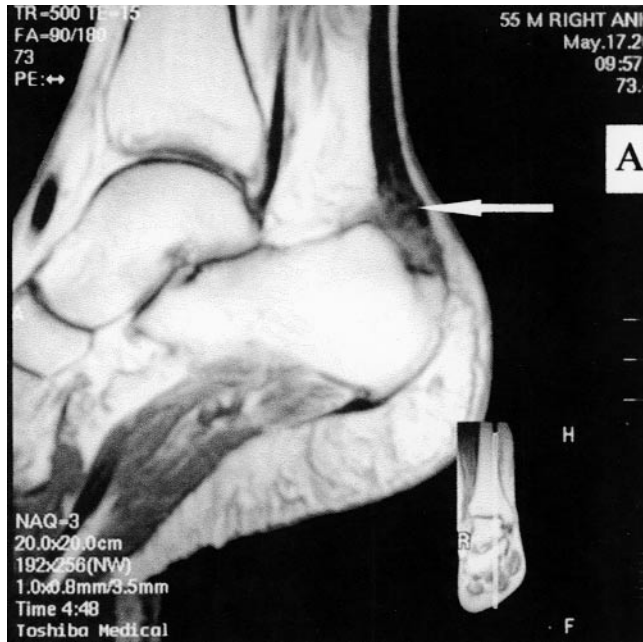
A. T1 weighted sagittal MR image of the heel showing tendinitis, intermediate intensity of the tendoachilles, and increased tendon thickness. B. Axial STIR sequence showing abnormal high intensity signals. C. Sagittal US image (12 MHz) showing thickened tendoachilles (1.08 cm) with minute calcific foci (large arrow) that were not detected on the MRI.
